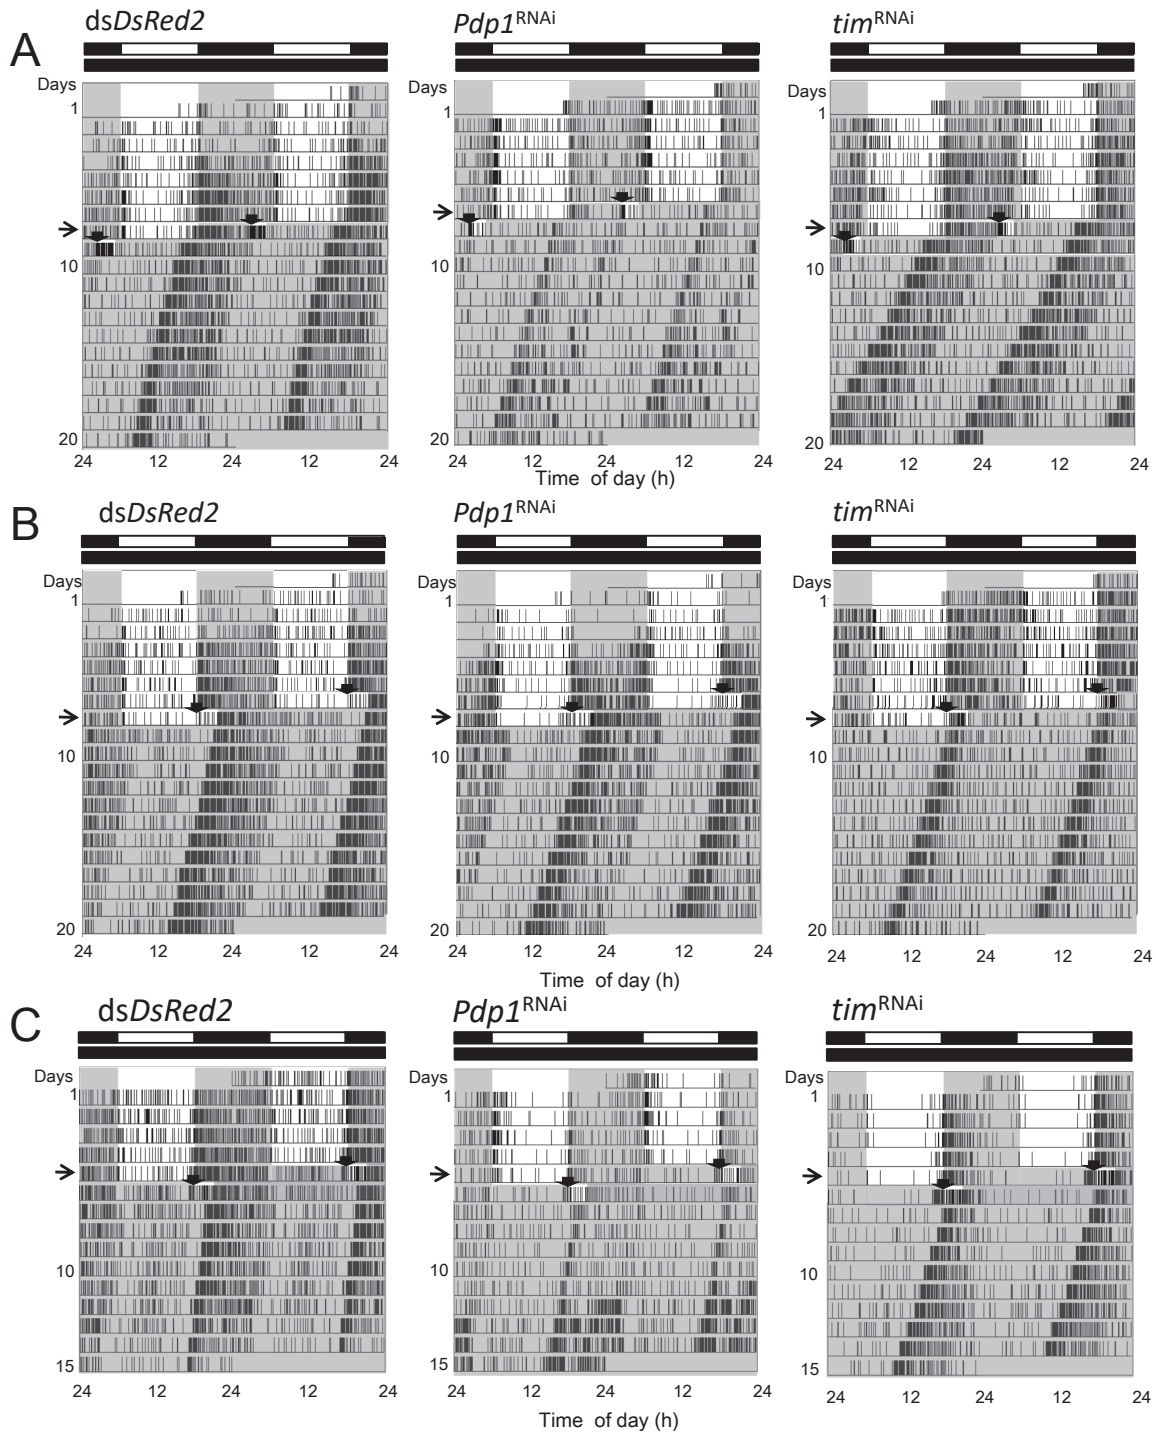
Phase shifts of locomotor rhythms caused by a 3 h light pulse given at (A) Zeitgeber time (ZT)20–23, (B) ZT12–15, or (C) circadian time (CT)12–15 in *dsDsRed2*-treated control, *Pdp1*^{RNAi}, and *tim*^{RNAi} adult male crickets *Gryllus bimaculatus*. Thick arrows in actograms indicate the start of a light pulse. Thin arrows on the left side of actograms indicate the day of transfer to constant dark (DD). DD started at 18:00 in (A) and (C), while at 21:00 in (B). For other explanations see legend of Fig. 2.
